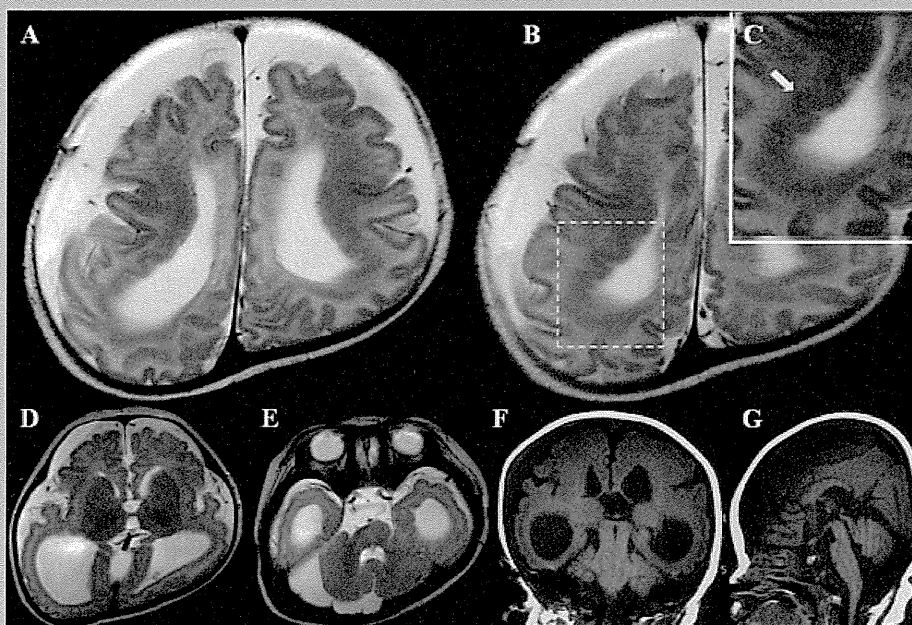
Brain MRI at 3 months of age. Axial T2-weighted (3500/90, TR/TE) images (A–E) revealed diffuse simple gyri with normal cortical thickness, enlarged lateral ventricles, and diffuse cerebellar hypoplasia. Symmetric laminar heterotopia encircling the lateral ventricles from the body to the posterior horns had an undulating ribbon-like appearance (arrow in C, a higher power view of B). Coronal (F) and sagittal (G) T1-weighted (642/13, TR/TE) images revealed partial agenesis of the corpus callosum.
